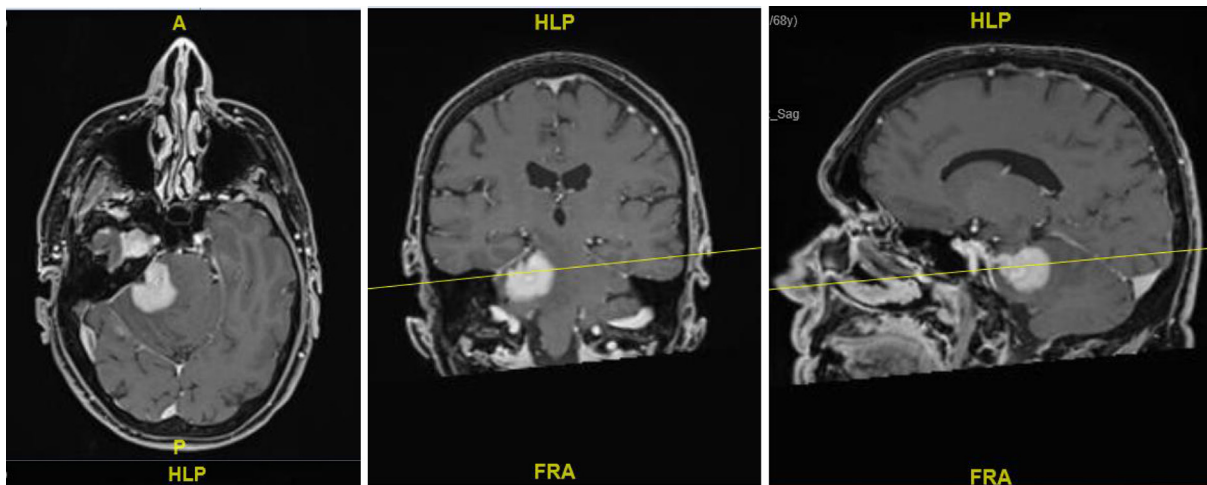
Preoperative postgadolinium T1-weighted MRI (A: axial, B: coronal, and C: sagittal). Avidly enhancing lobulated mass centered in the right cavernous sinus/Meckel's cave and CPA cistern causing moderate mass effect on the brainstem.
